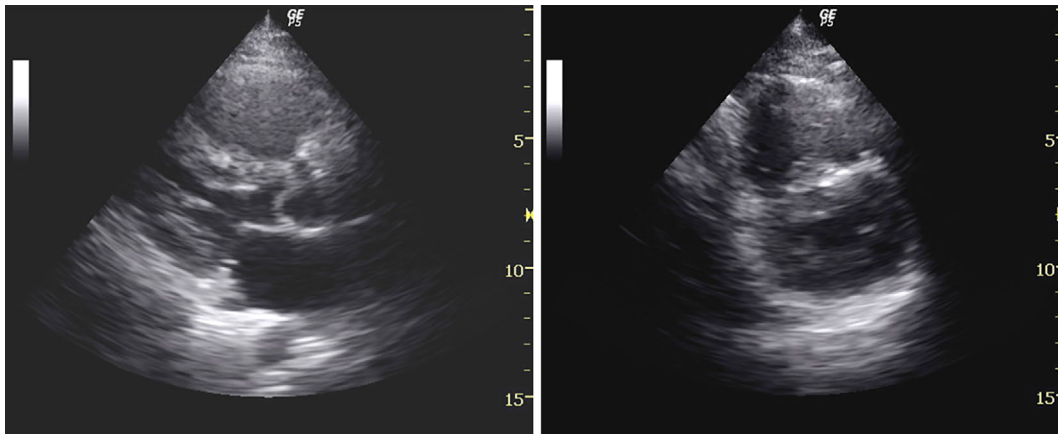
Bedside echocardiography. Echocardiography revealed a normal left ventricular systolic function and right ventricular (RV) dilatation with akinesis of the RV free wall.
